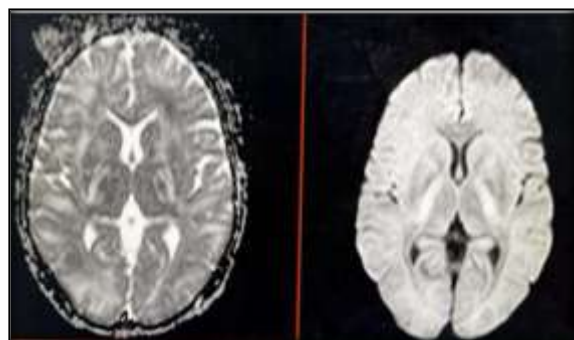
MRI Brain — ADC map (left) and DWI (right) showing patchy restricted diffusion in bilateral posterior limbs of internal capsules and occipitoparietal white matter
